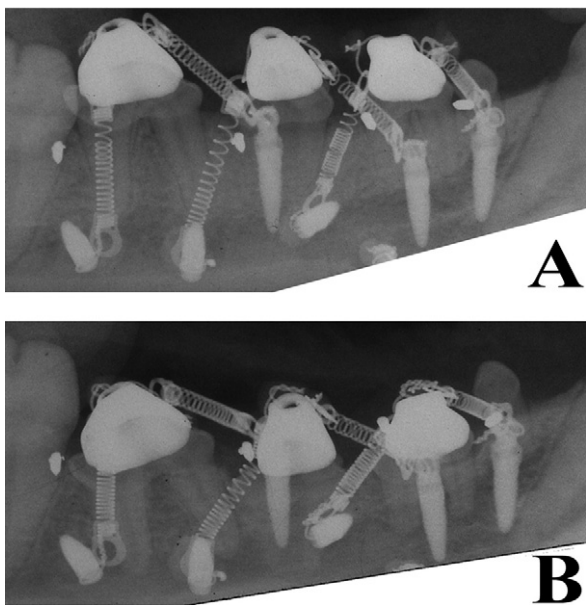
Periapical radiographs of LPM2, LPM3, and LPM4: A, Initial loading at day 0; B, after 98 days of constant loading.
